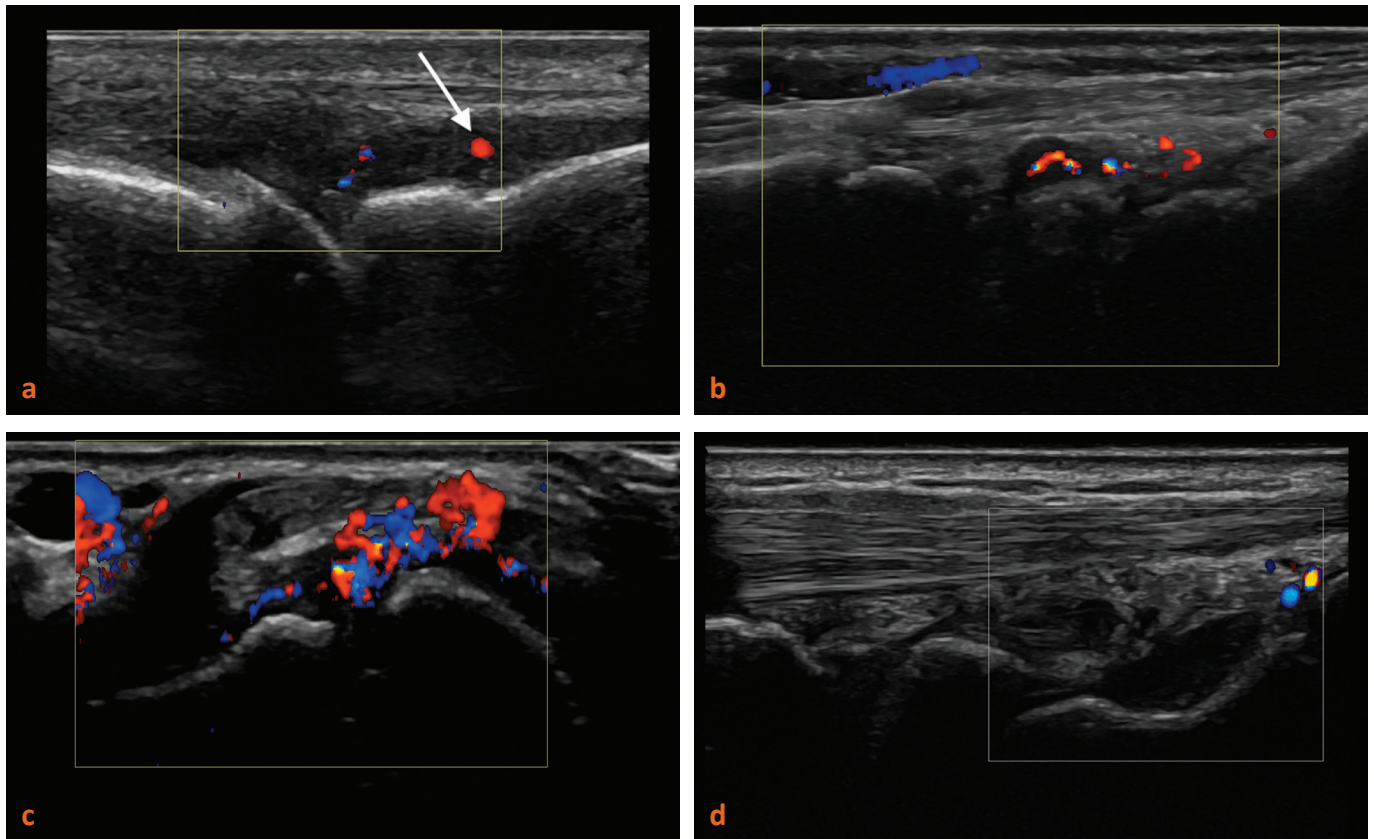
Synovitis classification in grayscale and color/power Doppler. (a) MCP joint in a patient with RA. Mild synovial thickening with single vessel signals (Grade I). (b) Radiocarpal joint in a patient with RA. Moderate synovial thickening. Confluent vessel signals, extent < 50% of synovium (Grade II). (c) PIP joint in a patient with RA. Severe synovial thickening. Confluent vessel signals, extent >50% of synovium (Grade III). (d) Radiocarpal joint in a patient with RA after therapy (in remission). Mild synovial thickening without flow signal (Grade 0) [normal vessels seen on the right side of the Doppler box].
